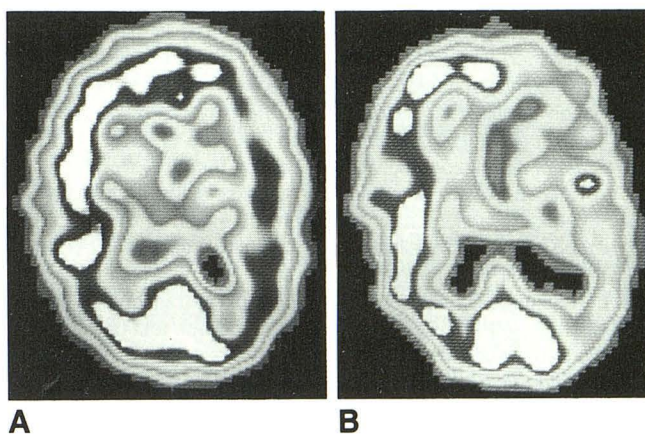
A, Baseline ^{99m}Tc-HMPAO SPECT image of patient 1 (Table 1) shows a relative reduction in perfusion of 9.7% in left middle cerebral artery (MCA) distribution.
